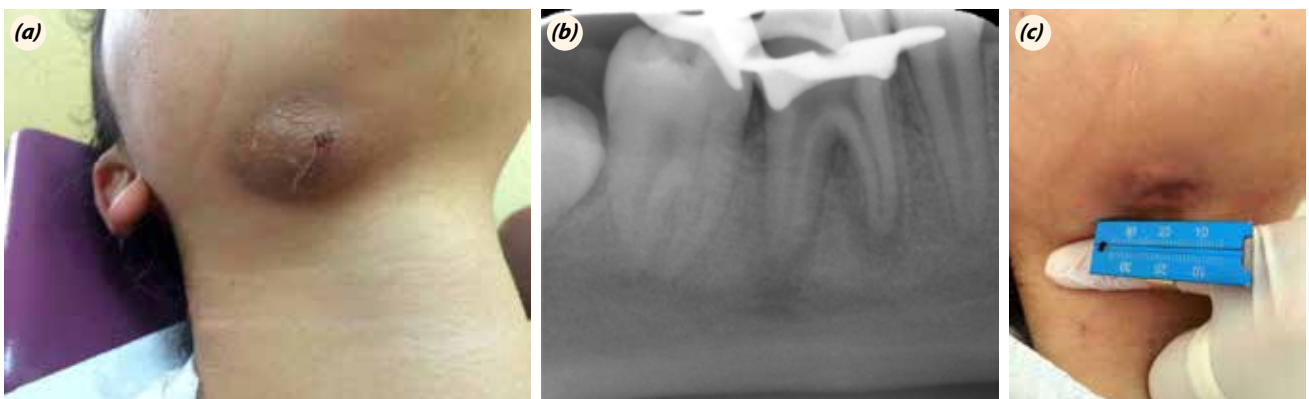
(a) Image of scab on the skin of the inferior chin border. (b) Diagnostic radiography of chronic apical abscess. (c) The diameter of fistula.
